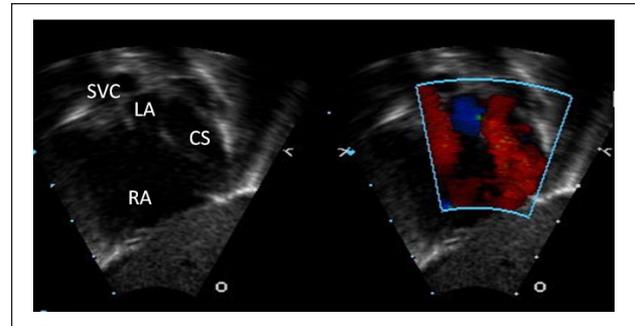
Transthoracic echocardiogram with subxiphoid short axis of TAPVC to the coronary sinus: the severely enlarged coronary sinus returns to the right atrium. Additionally, the right to left atrial shunt is visualized (blue color Doppler).
